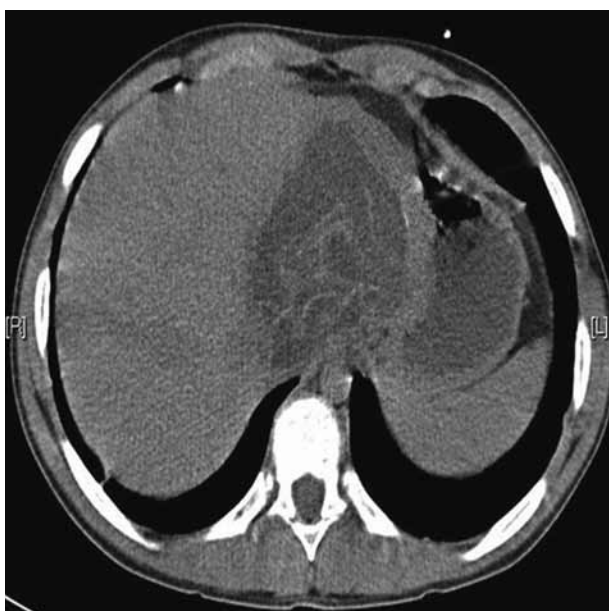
Computed tomography of liver : Solitary hydatid cyst with calcification (arrow) 8-9-7,5 cm in liver segment I-II.
